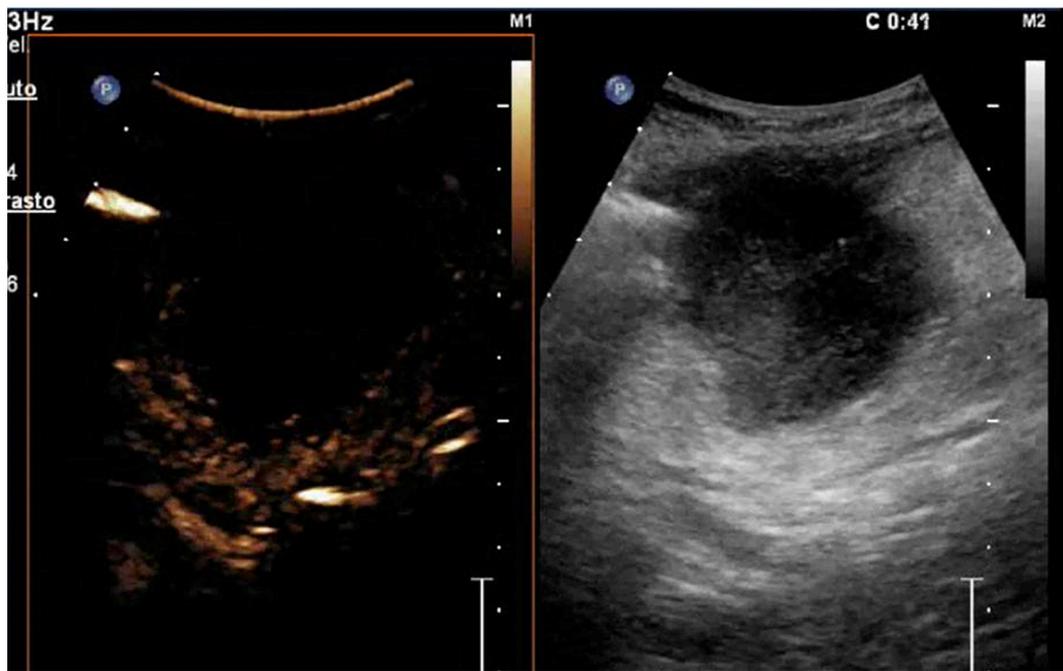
Portal phase of contrast enhanced ultrasound (CEUS) showing a clear rim enhancement, which is a sonographic sign suggestive for liver abscess.
